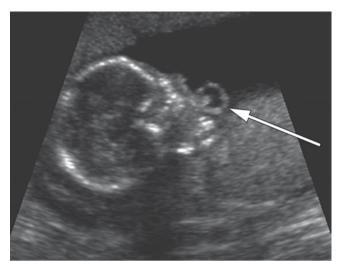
Oblique sonogram of a 16-week gestational age fetus demonstrates a 1 cm teratoma emanating from the right cheek into the amniotic fluid of an otherwise healthy 30-year-old gravida 4, para 1 woman
